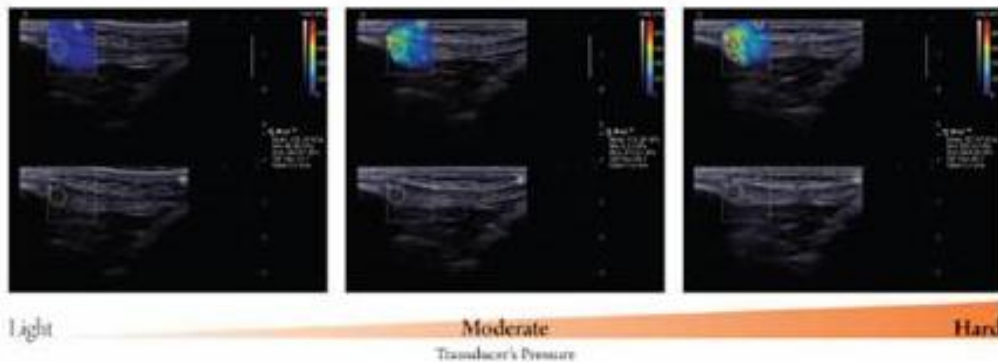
Longitudinal sonograms of patella tendon (PT) taken with different transducer's pressure. Upper images show color-coded box presentations of PT elasticity (stiffer areas were coded in red and softer areas in blue) superimposed on longitudinal grey scale sonograms of PT, with the circle representing the region of interest and its corresponding elastic modulus demonstrating under Q-Box™ on the right. Bottom images show longitudinal grey scale sonograms of PT on the identical scan planes. Transducer' pressure changed gradually from light to hard. The transducer was kept motionless for 8 to 12 seconds during the acquisition of the SWUE sonogram and ROI of 4 mm diameter was used. doi:10.1371/journal.pone.0044348.g002
